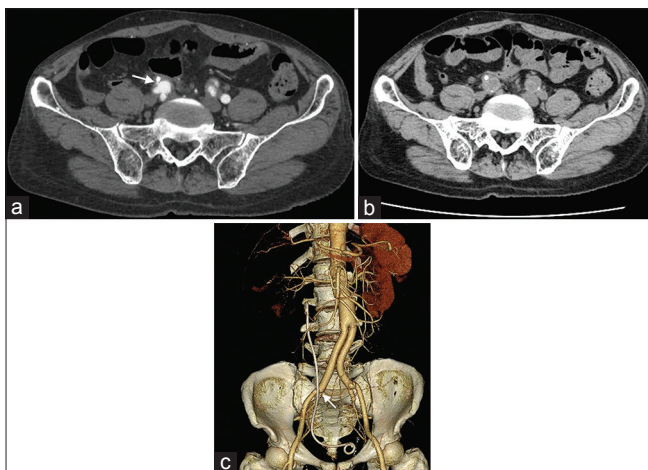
(a) Contrast-enhanced computed tomography (CT) in arterial phase shows a minimal process (arrow) that was a possible fistula between the right common iliac artery and the right ureter. (b) and (c) CT and 3D-CT angiography show that the right ureter with a ureteral stent crosses the distal site of anastomosis of the vascular graft (arrow)
